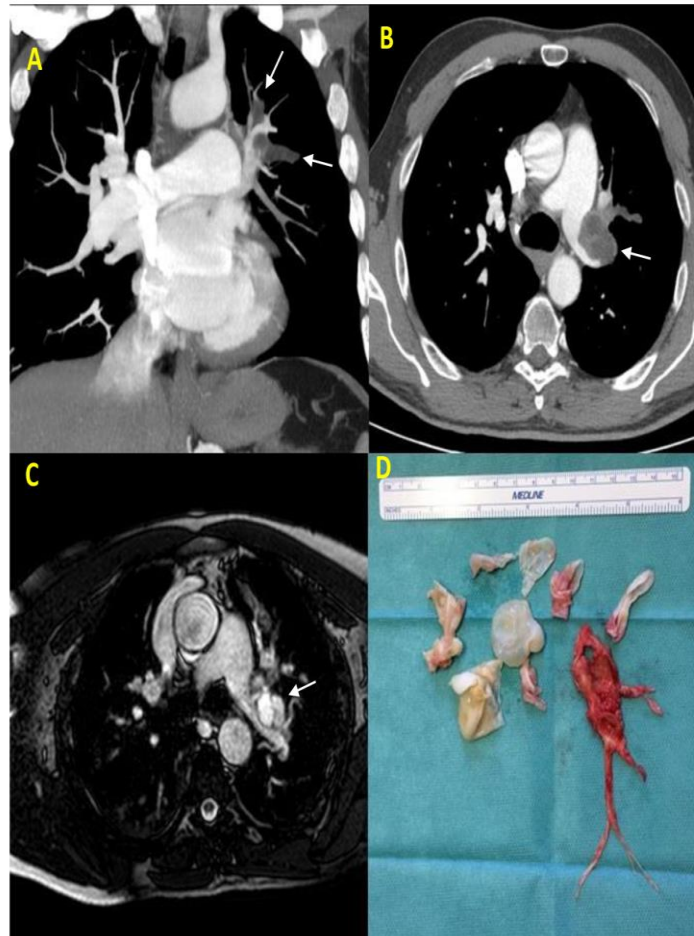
CT shows an intravascular filling defect in the main left pulmonary artery (2B) and in two left upper segmental arteries (2A). Pulmonary MRI confirms the diagnosis of HPE showing several daughter cysts into the left main pulmonary artery's lumen (2C). Intraoperative photograph shows all extracted hydatid cysts and the thrombotic component that surrounded them (2D)
